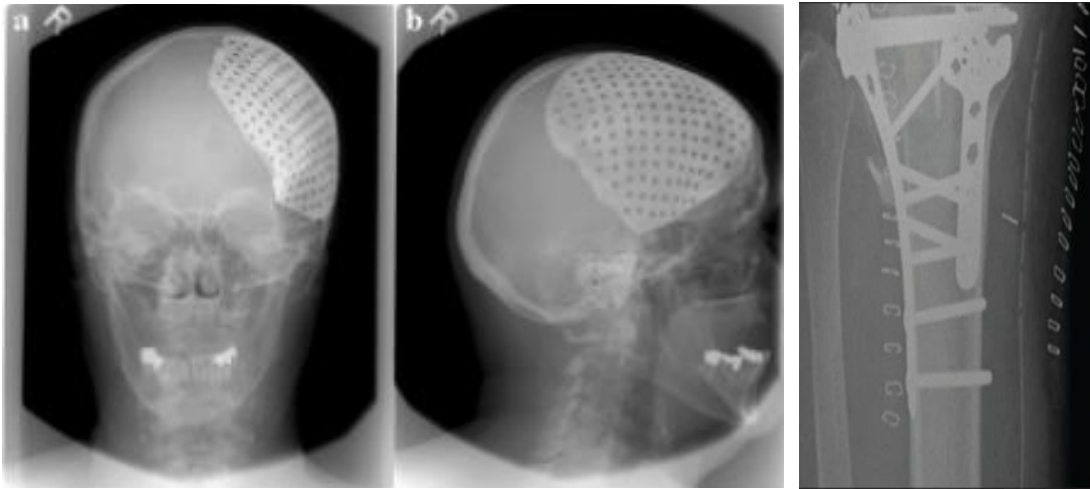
The x-ray radiographs of the skull on the left show an example of a titanium skull implant used after a decompression surgery [3]. The x-ray image on the far right is of a fractured tibia that required internal fixation using a combination of screws and plates [4].
